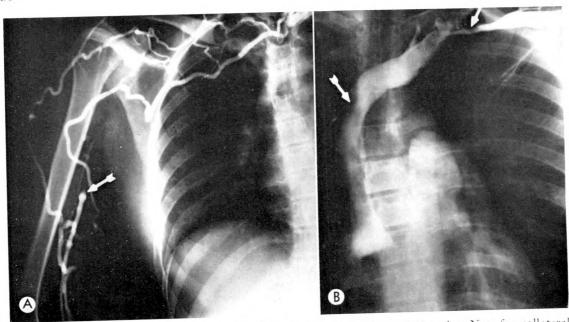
Case XI. (A) Chronic right axillary vein thrombosis (arrow) of I year's duration. Note few collateral channels. (B) Left arm injection (with arm elevated) showing point of phys.ologic stenosis of the left subclavian vein (upper arrow). The left innominate vein and superior vena cava are intact. Lower arrow points to site of entrance of right innominate vein. The failure to fill the right innominate vein after long serial roentgenography (see Fig. 4D) suggested that thrombosis had extended to the site of junction of the other innominate vein.
